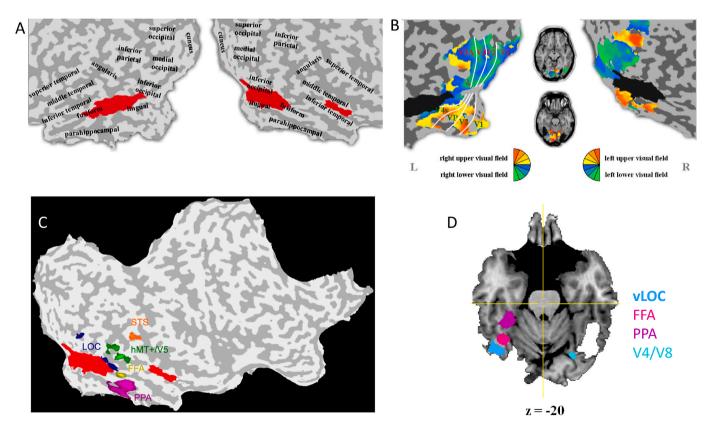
From Sorger et al.(2007).A.PS's cortical lesions displayed on flattened views of her posterior brain regions in MRI (compare to Fig.1).B.Visual field maps in PS's brain.While brain damage in the left hemisphere spared early visual areas, these maps could not be well-defined in the RH due to brain damage.C.A flattened map of PS's brain in MRI, with a number of functional regions around the cortical lesions (FFA, PPA, hMT+/V5, STS, LOC dorsal and ventral).Note the ventral portion of the vLOC abutting the extensive right IOG lesion.This is represented in D.in a transverse slice of PS's brain, showing the sparing of the right middle fusiform region, where the FFA is located, and the right vLOC.These functional regions were not found in the left hemisphere (Sorger et al., 2007).
